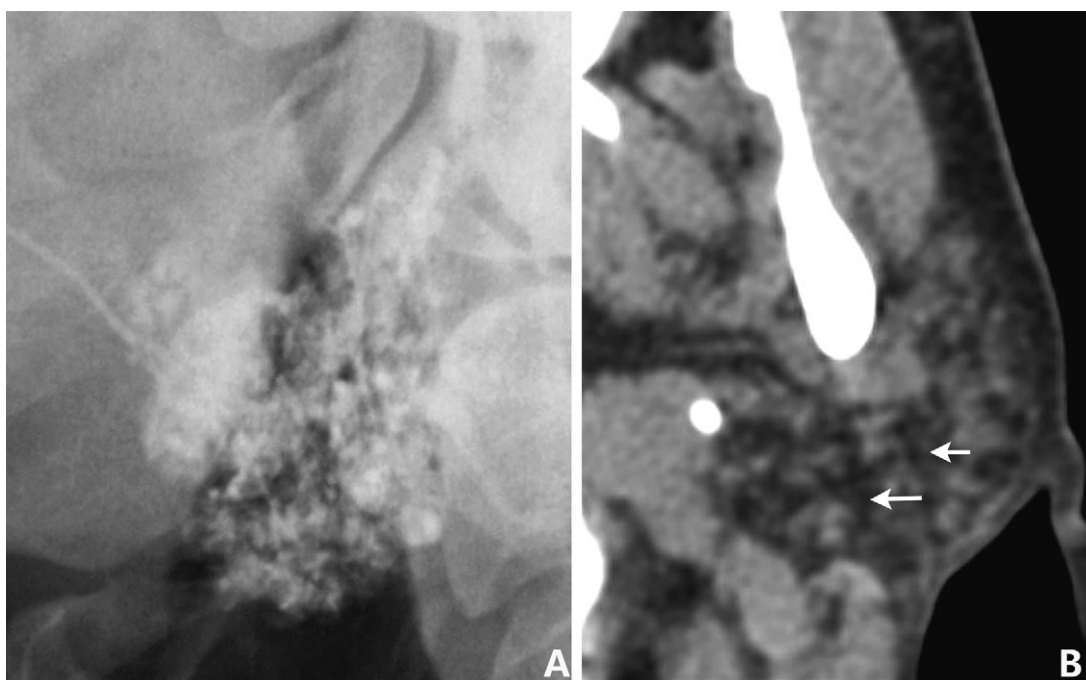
Sialogram and CT in stage 3 of SS. The areas of sialectasis coalesce, enlarge and become irregular (A) in a stage 3 patient and large areas of adipose tissue attenuation (like patches or streaks, less than 50% of total parotid gland area) are observed (B, white arrows) on CT of the same patient (60-year-old, female).
